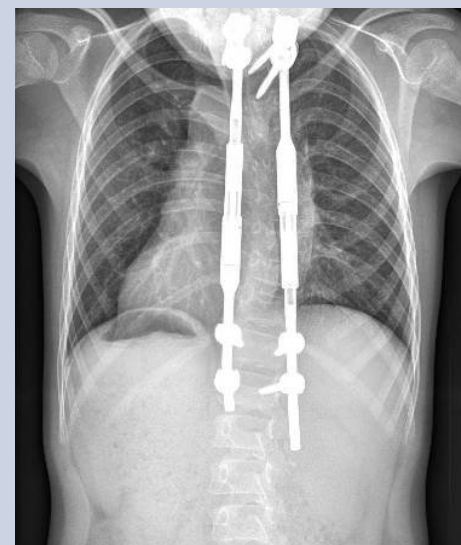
X-ray scan showing a reduction of spinal curvature to a Cobb angle of about 25° eight months after the implantation of the MAGEC rods.
